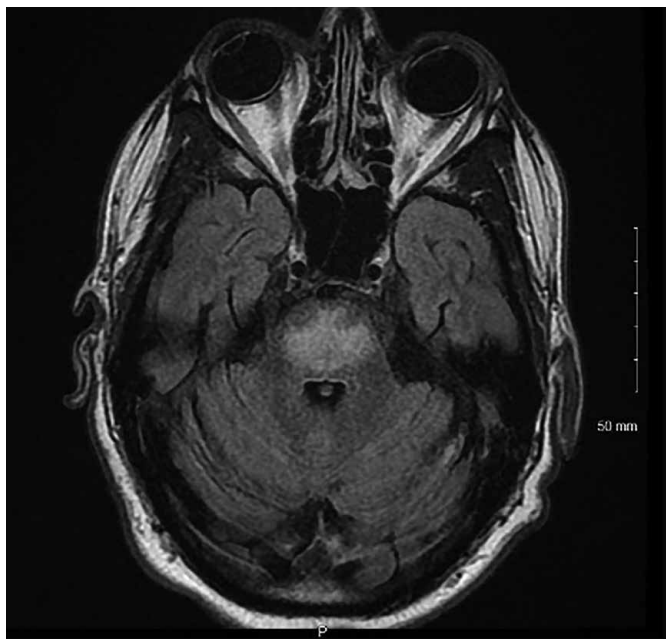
Magnetic Resonance Imaging demonstrating pontine infarction or osmotic demyelination. This scan represents a similar scan to the one obtained in the patient above.²²
